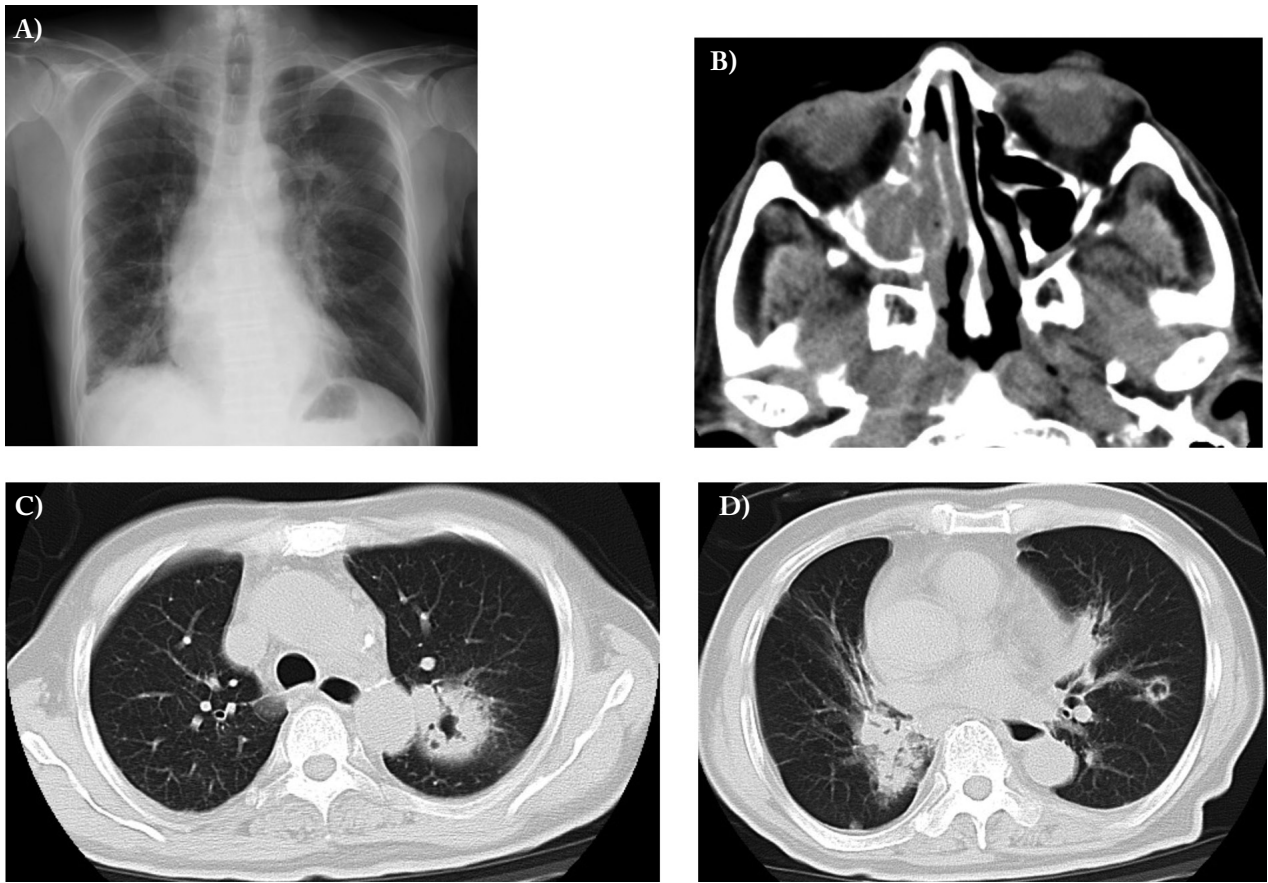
Radiological findings. Chest X-ray (A), paranasal sinus computed tomography (CT) (B), and chest CT (C, D) and administered at admission
